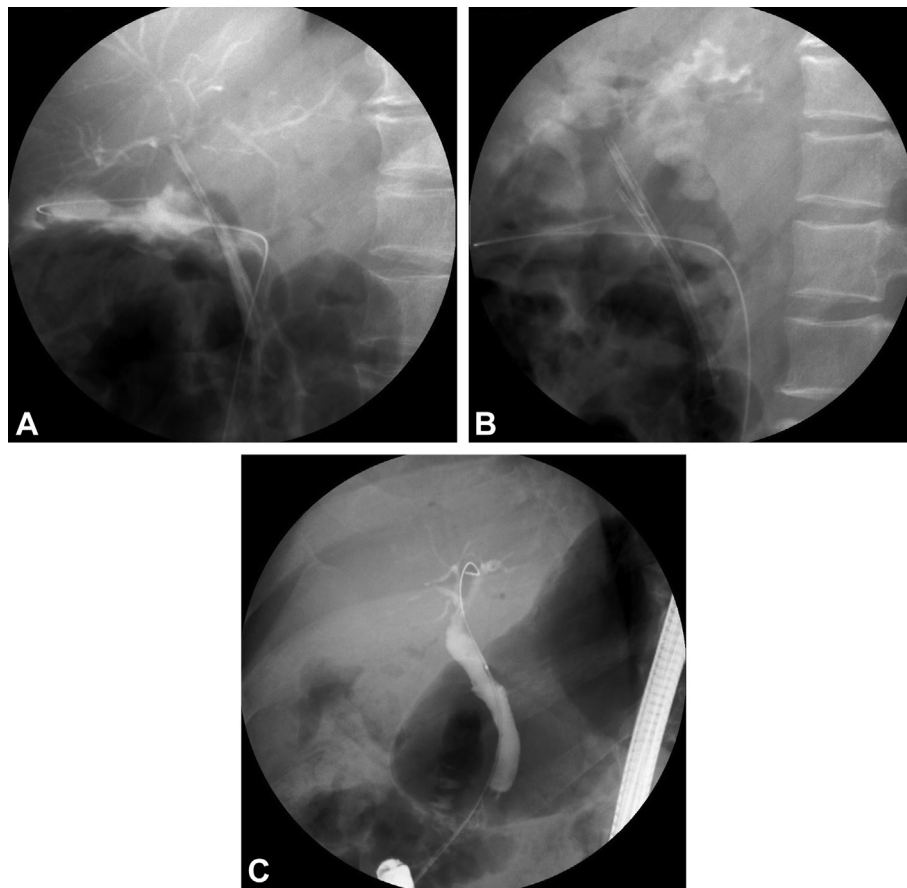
Endoscopic management of a refractory biliary leak by using multiple plastic stents. A, Fluoroscopic image showing persistence of a bile leak and persistence of biliary drainage through the percutaneous drain after 15 days of plastic stenting. B, Radiograph immediately after endoscopic placement of 3 plastic stents for endotherapy of a refractory bile leak. C, Follow-up cholangiography after plastic stents removal. No contrast media extravasation is seen.
